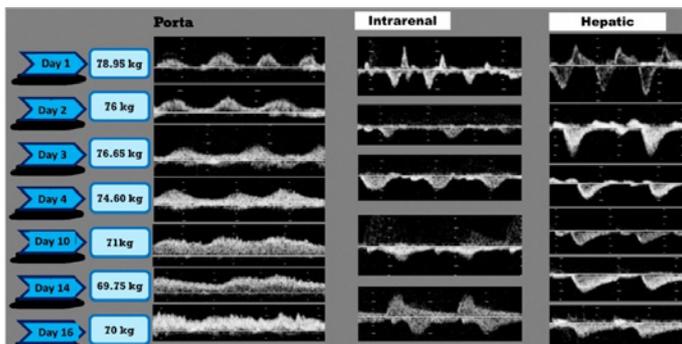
Evolution of intravascular congestion between days 1 and 16 assessed using the VExUS protocol (venous Doppler of the portal vein, intrarenal veins, and hepatic veins) and correlation with weight variation.
